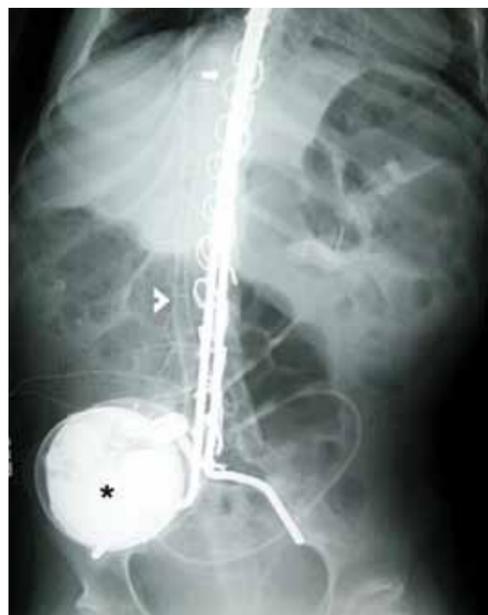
A radiograph demonstrating the integration of an intrathecal baclofen pump (*) and catheter (arrow) with other interventions. In addition to spastic quadriplegia, this patient had multiple other difficulties secondary to preterm birth, including shunted hydrocephalus (arrowhead), scoliosis requiring a spinal fusion, and a gastrostomy tube. Comprehensive coordination of care is essential to optimizing this child's quality of life.
